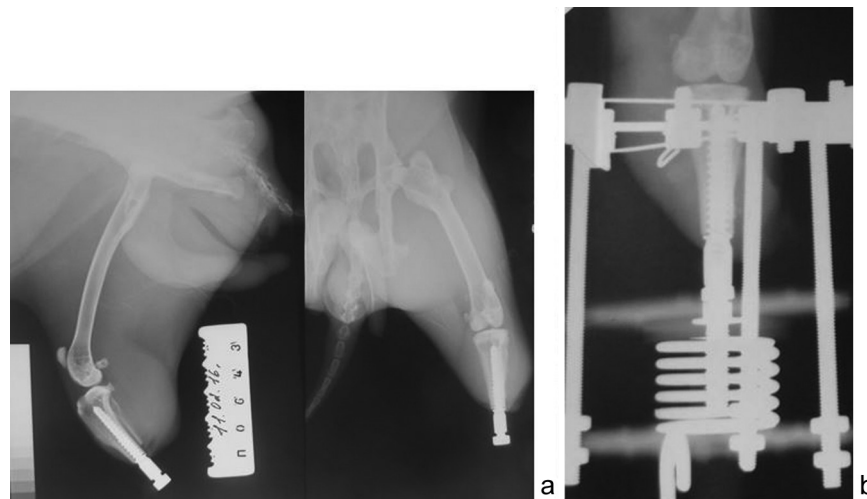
Postoperative radiographs of pelvic limb showing (a) the implant placed in tibia, (b) compression device attached
